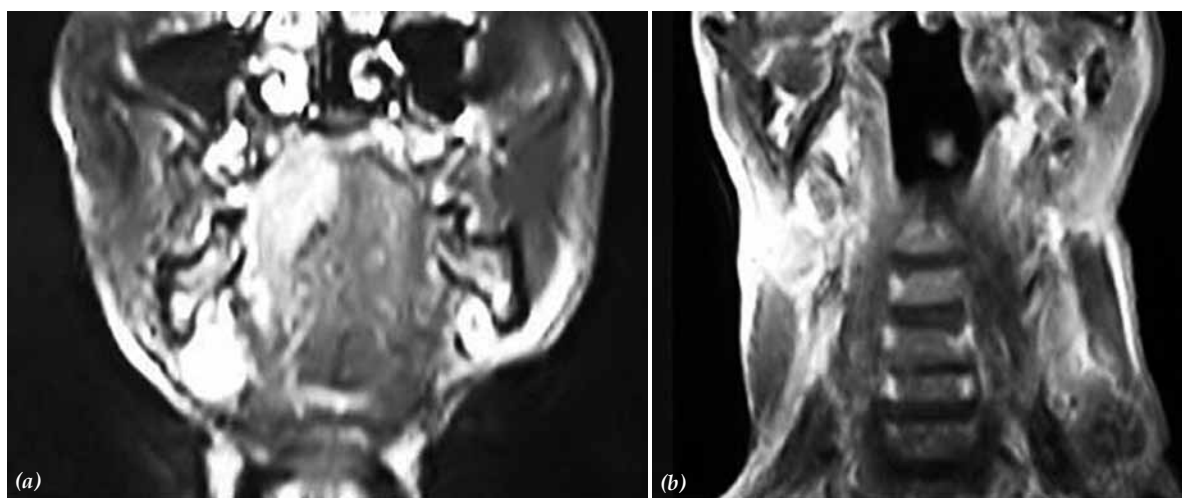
MRI showing (a) a mass on the left side of the tongue involving the base and the mid-line and (b) bilateral multiple cervical lymph node metastasis.
